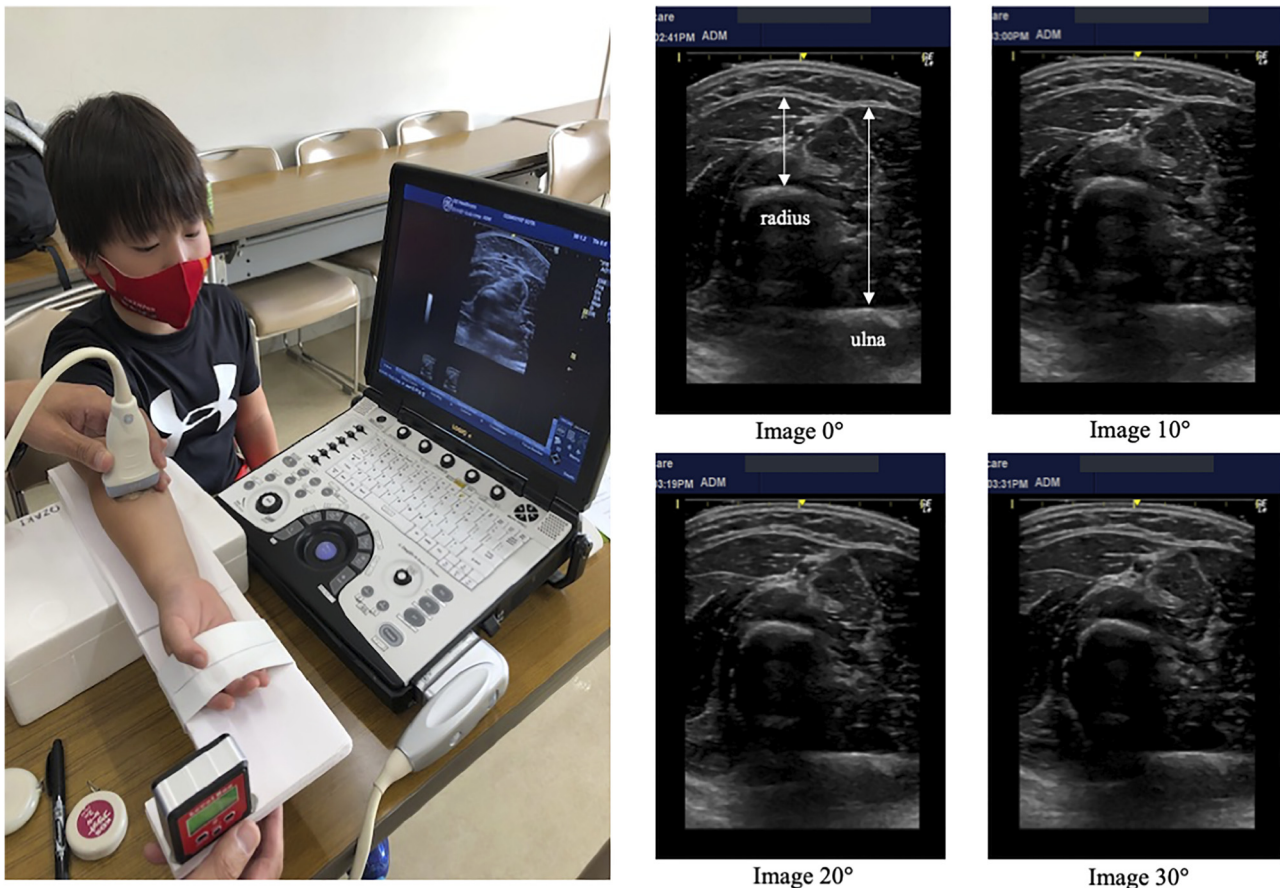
Experimental setup used in this study. An expanded polystyrene board (7 mm thickness) was separated into two parts, and the top (on which the hand rested) was designed to rotate. The electronic level (bottom left of the photo) was first calibrated for each individual, and  $0^\circ$  was a parallel of the two boards on the forearm and hand. The ultrasound probe was never taken off the surface of the skin until all images were taken. The right side of the figure is a typical ultrasound image at each angle
